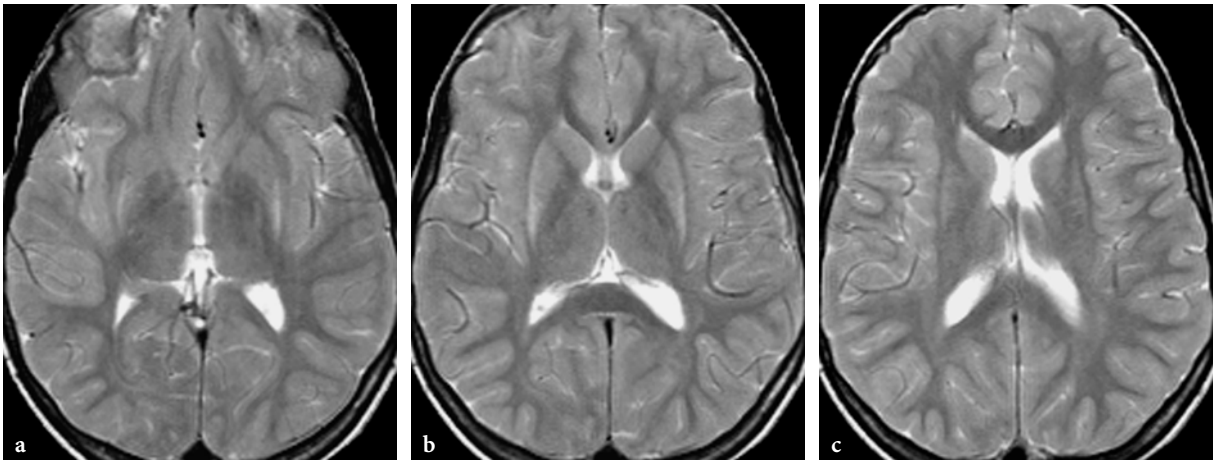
MR imaging findings in an 11-year-old male patient with α -ketoglutaric aciduria. a–c Axial T2-weighted fast spin-echo images. In this patient, only partial putaminal lesions are present, while the caudate nuclei and the thalami are spared. Signal abnormalities and atrophic changes involve the lateral and the posterior parts of the putamina
